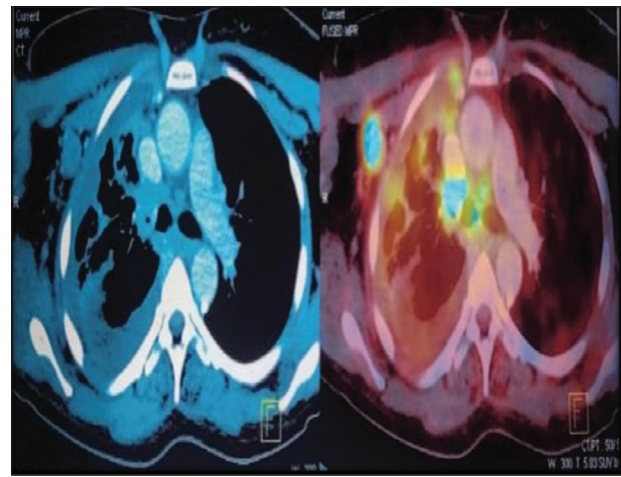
Axial section of contrast enhanced CT scan and axial section of 18F-FDG PET-CT scan with hyper-metabolic and enhancing soft tissue mass involving the supra-hilar region of right lung causing mass effect on the adjacent right bronchus
